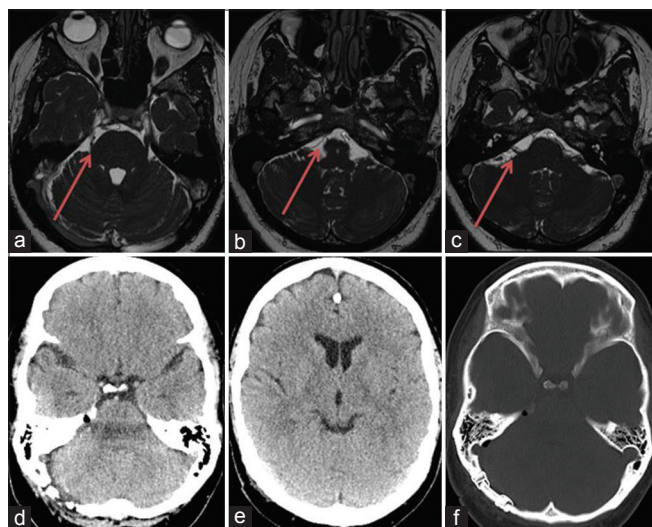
MRI images (a-c) showing microvascular confliction of SCA with trigeminal nerve (a) and AICA with facial nerve (b and c). Postoperative cranial CT scan is showing no complications (d-f)
